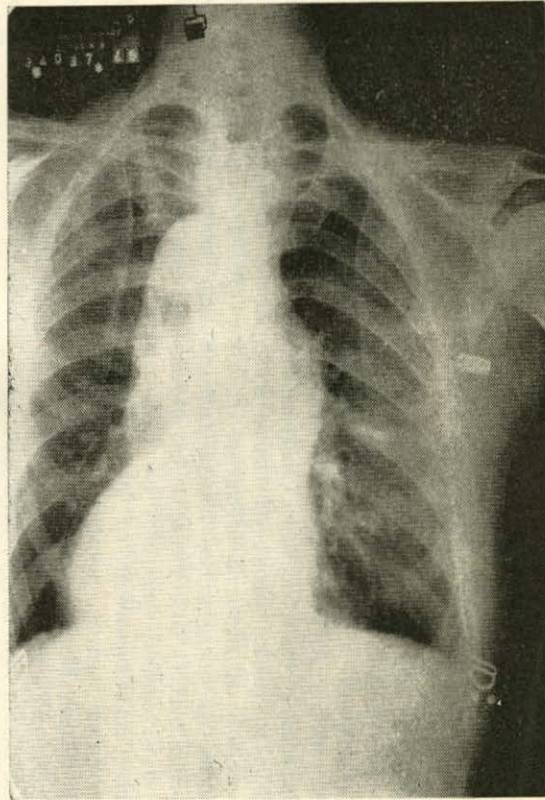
X-ray on 11-9-45. Disappearance of fluid following treatment.
